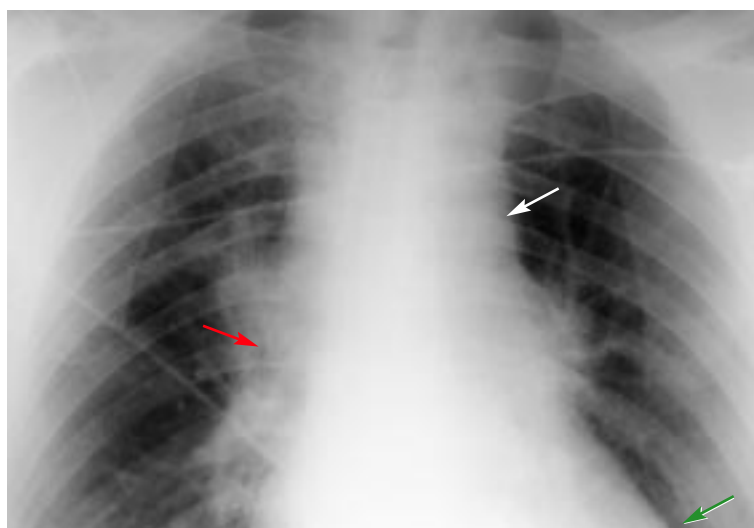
Portable radiography reveals mild superior mediastinal widening (white arrow), prominent right hilum (red arrow), and bilateral lower lobe discoid atelectasis (green arrow).
